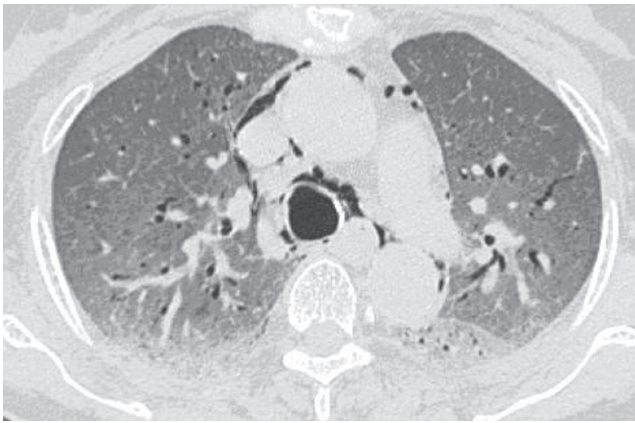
Computed tomography (CT) image of the patient. Extensive pneumomediastinum was noted.
